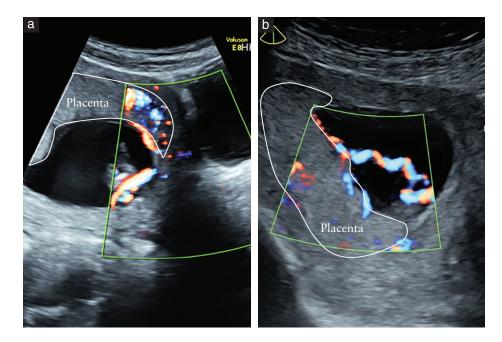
Ultrasound images showing velamentous (a) and central (b) cord insertion into placenta at 11-13-week scan.
